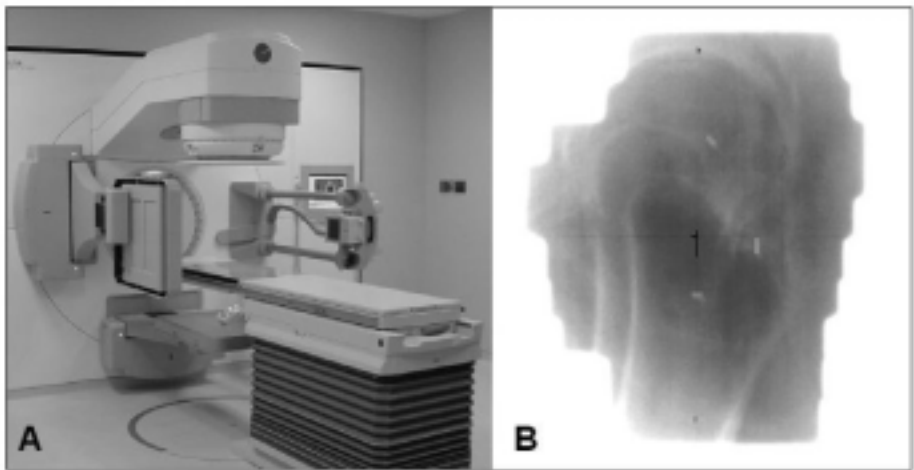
(a) A medical linear accelerator with an electronic portal imaging device and an experimental kilovoltage imaging device mounted orthogonally, and (b) a portal image for a lateral radiation beam. The implanted seeds appear as three small high density objects. The irregular outline of the radiograph demonstrates the extent of the radiation field.
